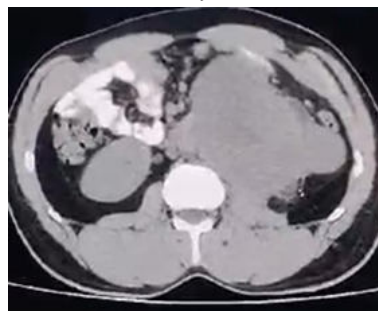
CT finding showing retroperitoneal lymphadenopathy
